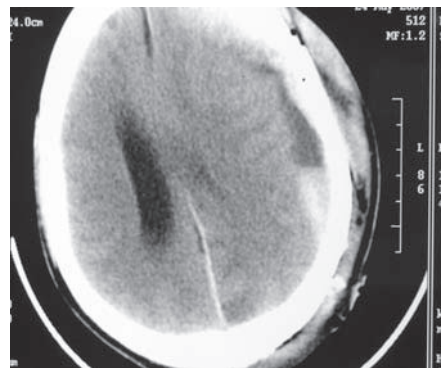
Immediate post-operative CT scan showing evacuation of EDH and redistribution of subdural blood, with blood-CSF level.
